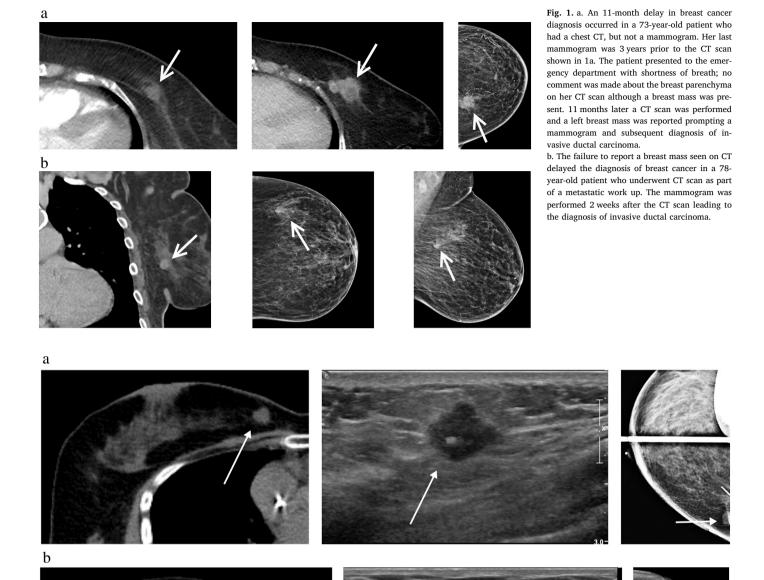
a. 37-Year-old patient with poorly differentiated Invasive ductal carcinoma. CT shows an irregular mass in the far medial right breast which is easily seen on ultrasound as a hypoechoic irregular mass, but is only able to be partially seen on mammography even when the technologist was able to place a marker on the palpable mass.
